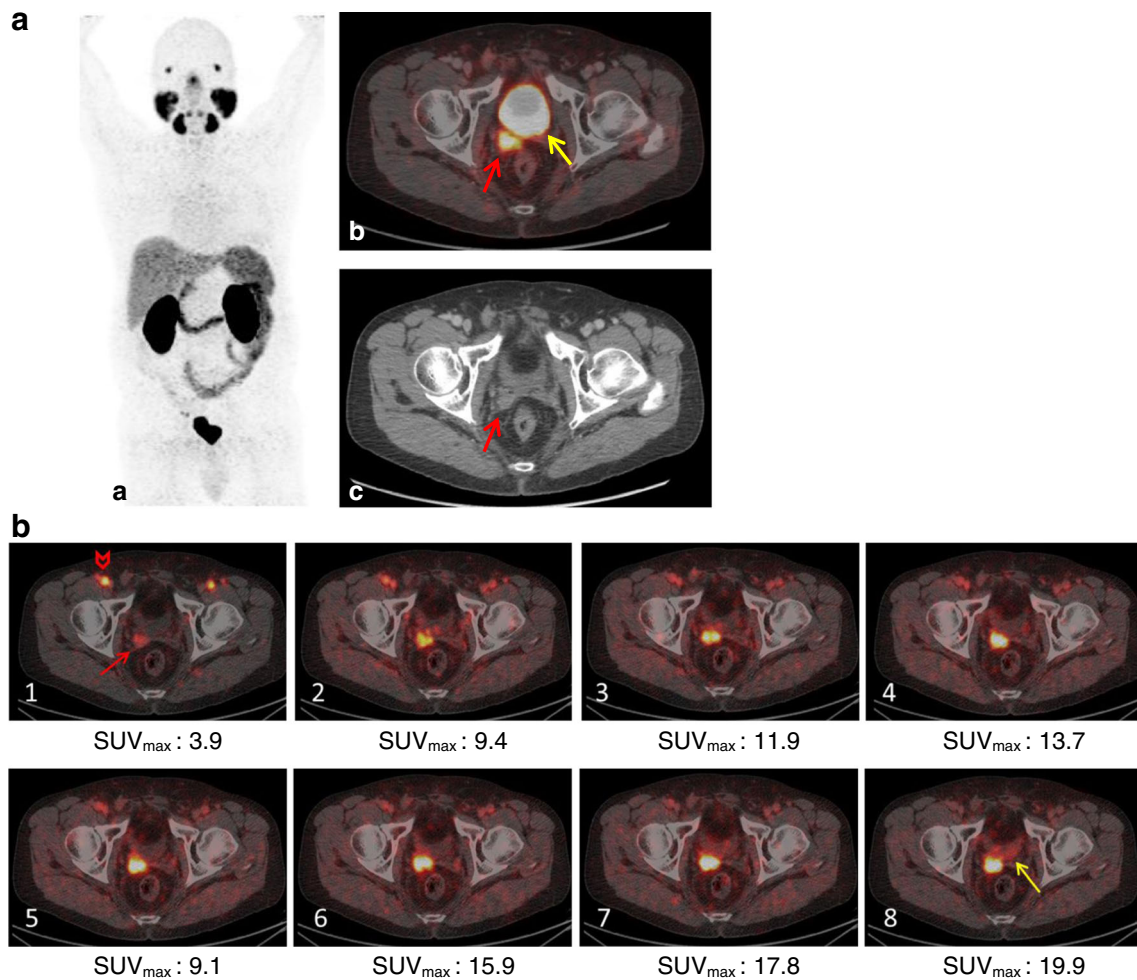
a ⁶⁸Ga-PSMA-11 PET/CT in a PC patient with biochemical recurrence (PSA: 2.2 ng/mL). b Maximum intensity projection (a), fused PET/CT (b), and ceCT (c) of whole-body PET 60 min p.i. with a
